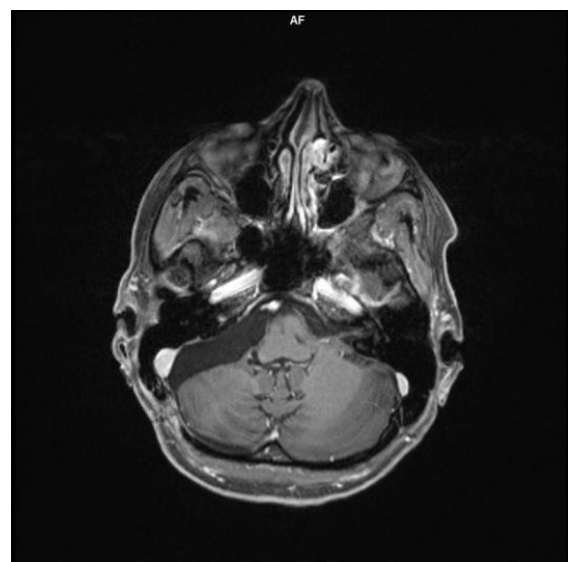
The T1-weighted contrast-enhanced MR image taken after the surgery shows no tumor remnants or postoperative complications
